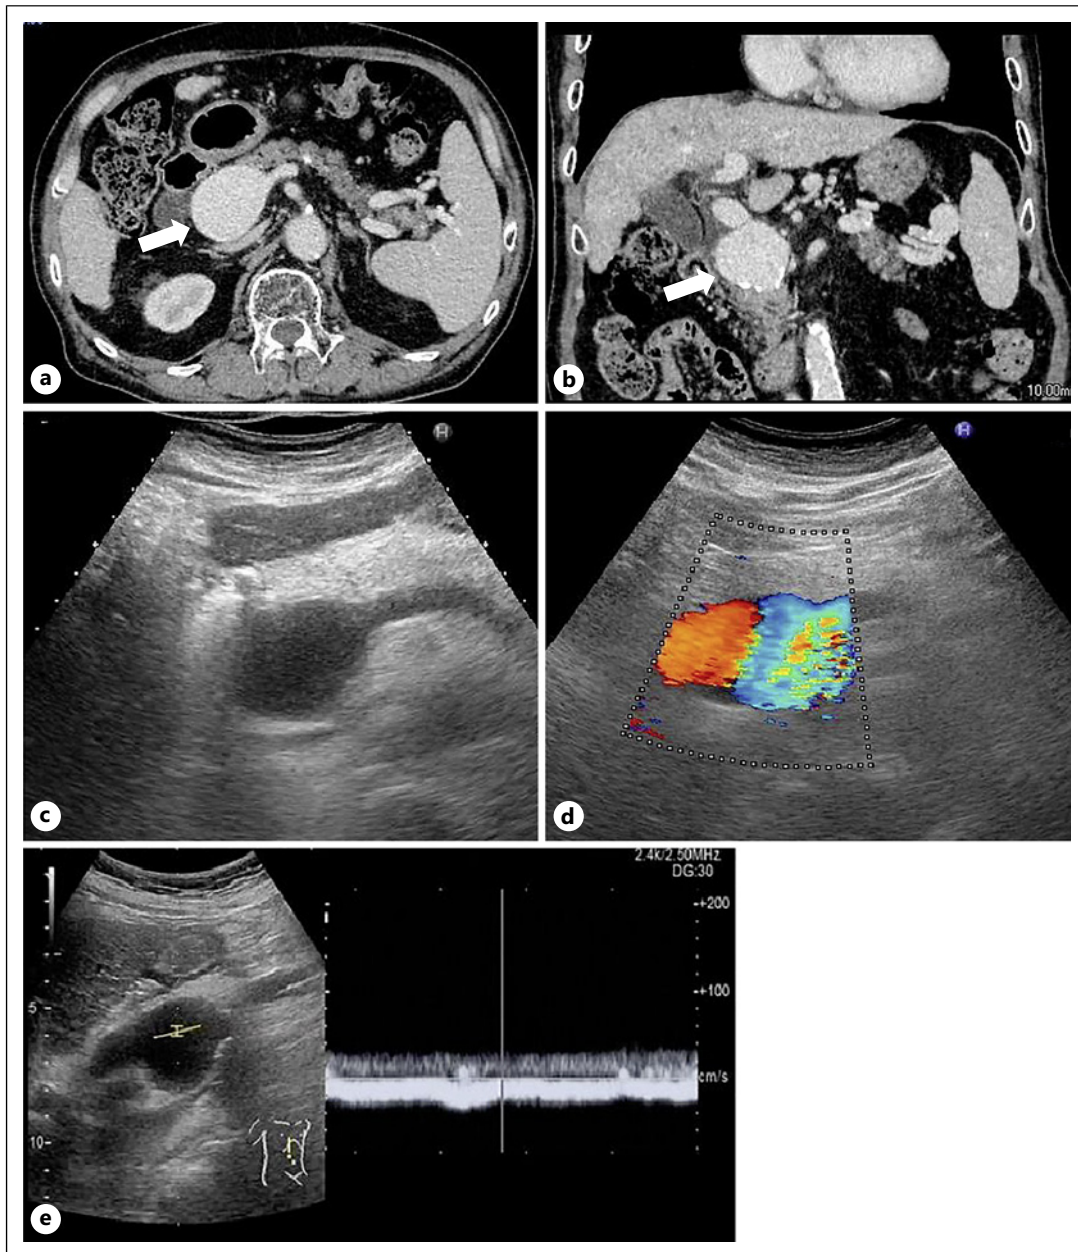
Images at initial diagnosis of the PVA in 2004 (a–c) and thrombus in the PVA in 2010 (d, e). Axial (a) and coronal (b) plane images of contrast-enhanced CT show an enhancing ovoid lesion at the confluence of the splenic vein and superior mesenteric vein (arrows). The abdominal ultrasound image shows an anechoic dilatation of the portal vein through the short (left) and long (right) axes on subcostal view (c). Axial (d) and coronal (e) plane images of the contrast-enhanced CT show the enlarged PVA with internal thrombus (arrows).
